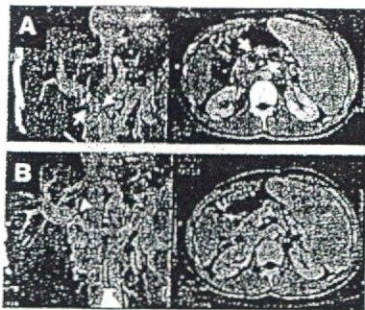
Multidetector three-dimensional computed tomography (3D CT) angiography before (A) and after (B) the systemic thrombolytic therapy in case 4. Before the treatment, the thrombus extended from the splenic vein confluence to the portal vein anastomosis (arrow). Although the entire thrombus disappeared after the treatment, an anastomotic stricture remained (arrowhead).
